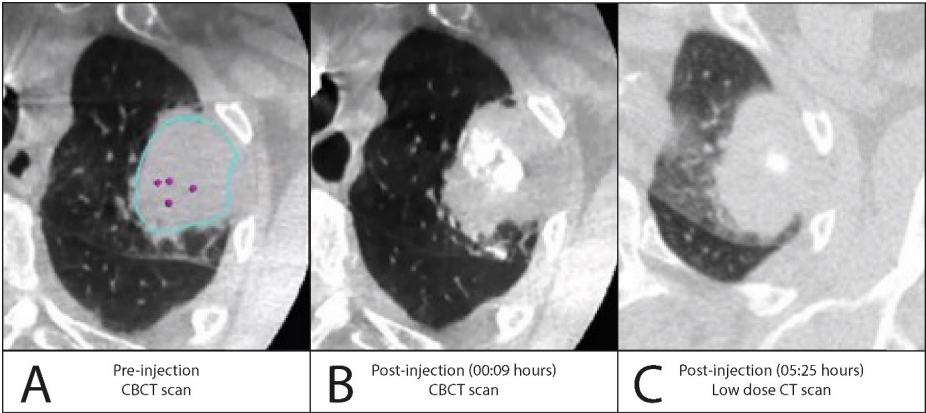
Visualization of the visibility of lomeron 300 before injection (CBCT scan) directly after injection on a CBCT scan and after 05:25 hours on a low dose CT scan. We can clearly see the dissipation of lomeron 300 in the first scan and at a later scan time, the contrast agent as almost completely dissolved. (CB)CT, (cone-beam) computed tomography.
